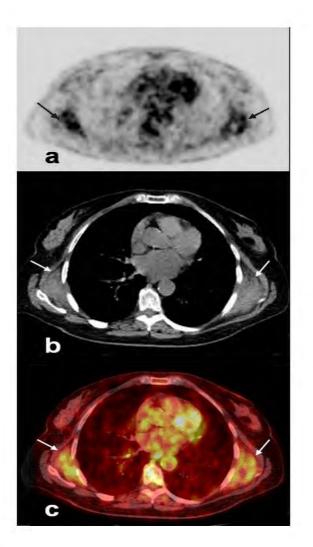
78 year old female with elastofibroma dorsi. In view of PET (a), CT (b) and fusion (c) images obtained in the axialplane, orientation to localization of the lesion is also easier, FDG uptake is observed as deep-located in serratus anterior muscle in infrascapular localization.
